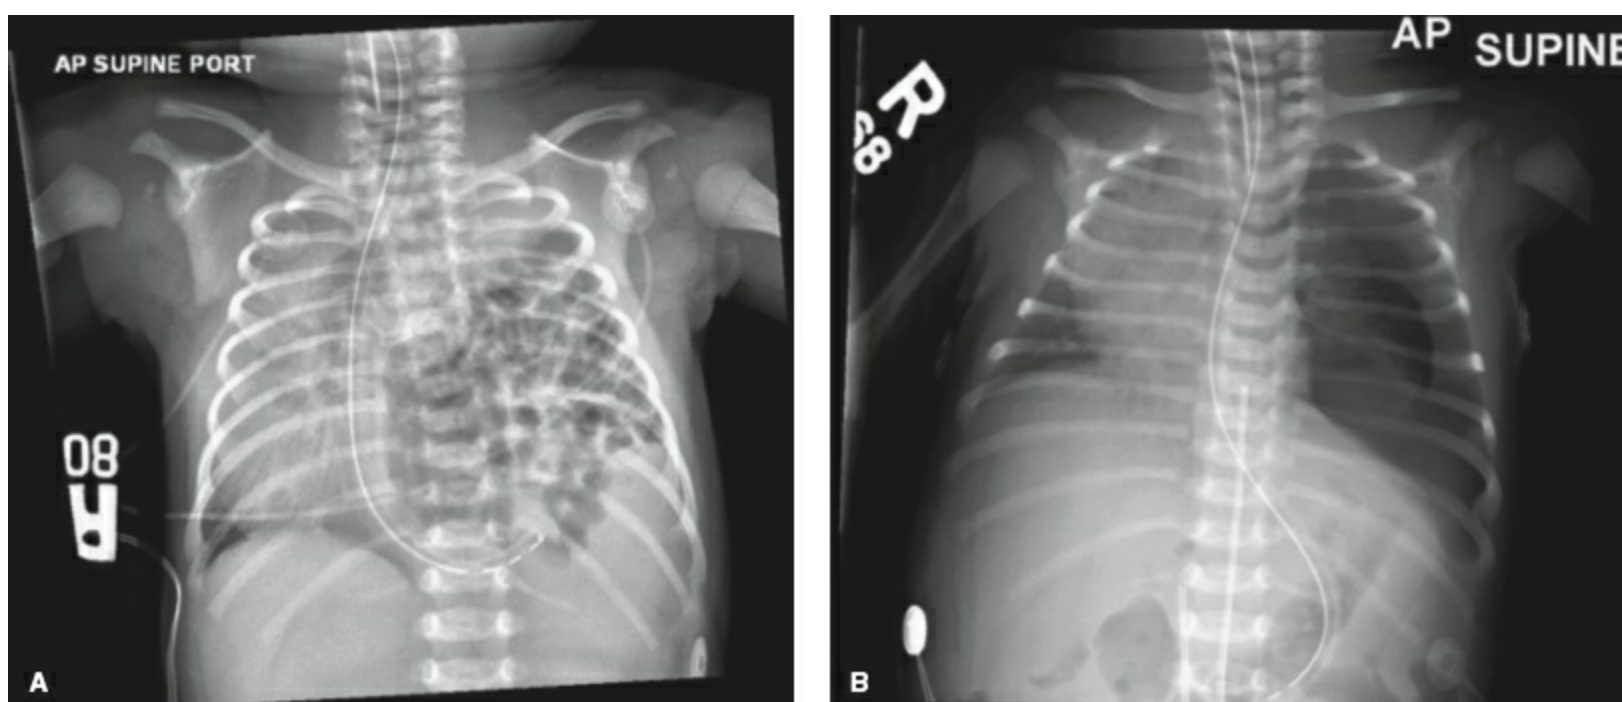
A: Chest radiograph of a newborn with a left congenital diaphragmatic hernia. Mediastinal structures are shifted to the right. Abdominal viscera occupy the left hemithorax. The nasogastric tube locates the stomach. The child underwent repair of the congenital diaphragmatic hernia after treatment and resolution of pulmonary hypertension. B: Immediate postoperative photograph demonstrates hypoplastic lung, flattening of diaphragm, and return of abdominal viscera to normal position.
